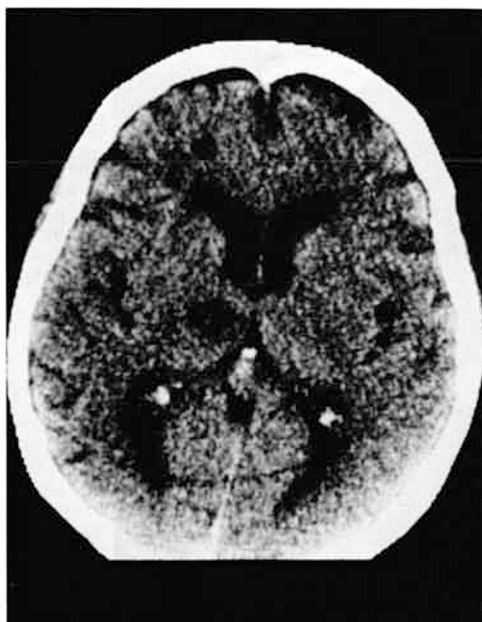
CT scan of patient 3. Left medial thalamic infarct.
